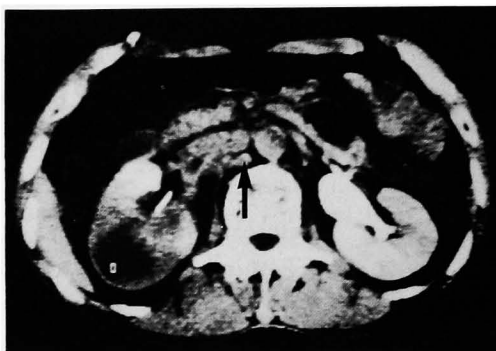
Contrast-enhanced CT showed a low density mass in the right kidney and hilar lymph node involvement (arrow).
